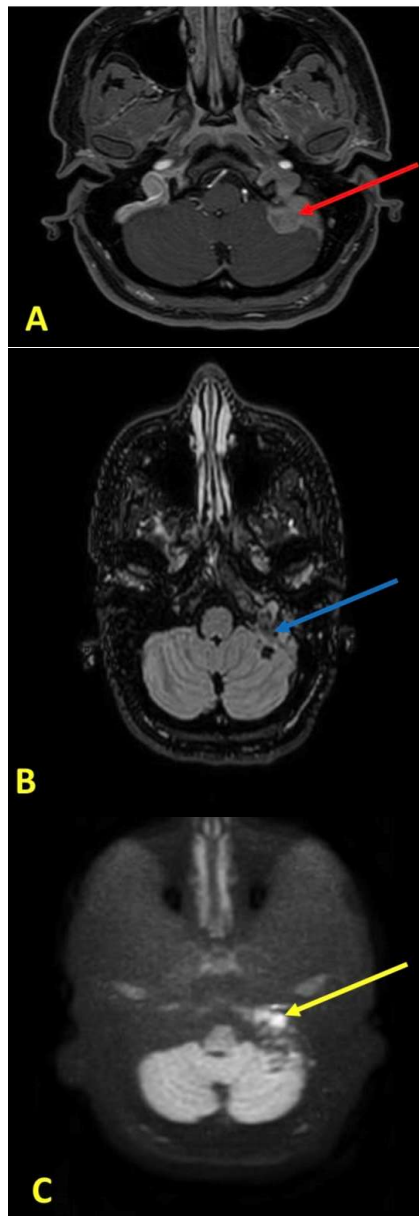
MRI of the Cerebellopontine Angle.
